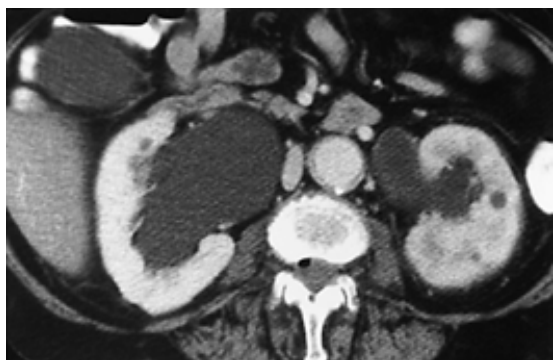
29. Acute pyelonephritis of the left kidney in a patient with bilateral hydronephrosis due to bladder outlet obstruction. Note the patchy and irregular nephrogram in the left kidney. This appearance cannot be separated radiographically from changes due to acute obstruction. There is also a small cyst in the left kidney.
